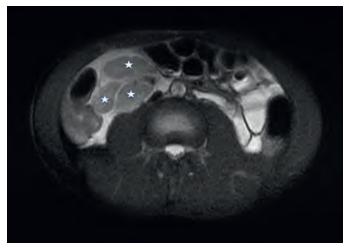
4 Abdominal MRI with *Yersinia* mesenteric adenitis. White stars indicate enlarged mesenteric lymph nodes. (*Courtesy Tara Palmore, MD.*)
